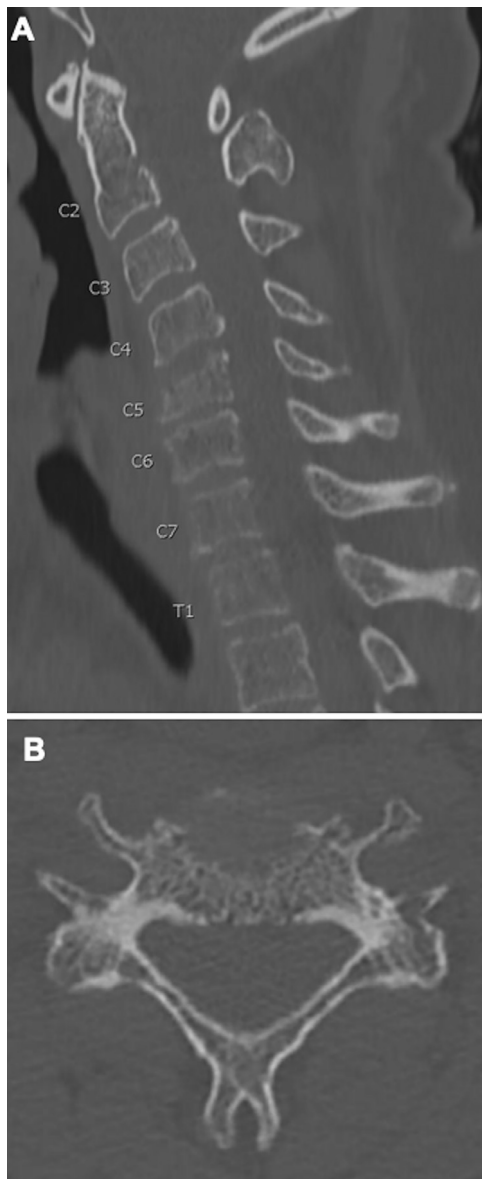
Panel A shows a sagittal cut and Panel B shows an axial cut of a cervical spine CT scan showing a compression deformity of C5 vertebral body with an associated kyphotic deformity at the C4–5 level.
